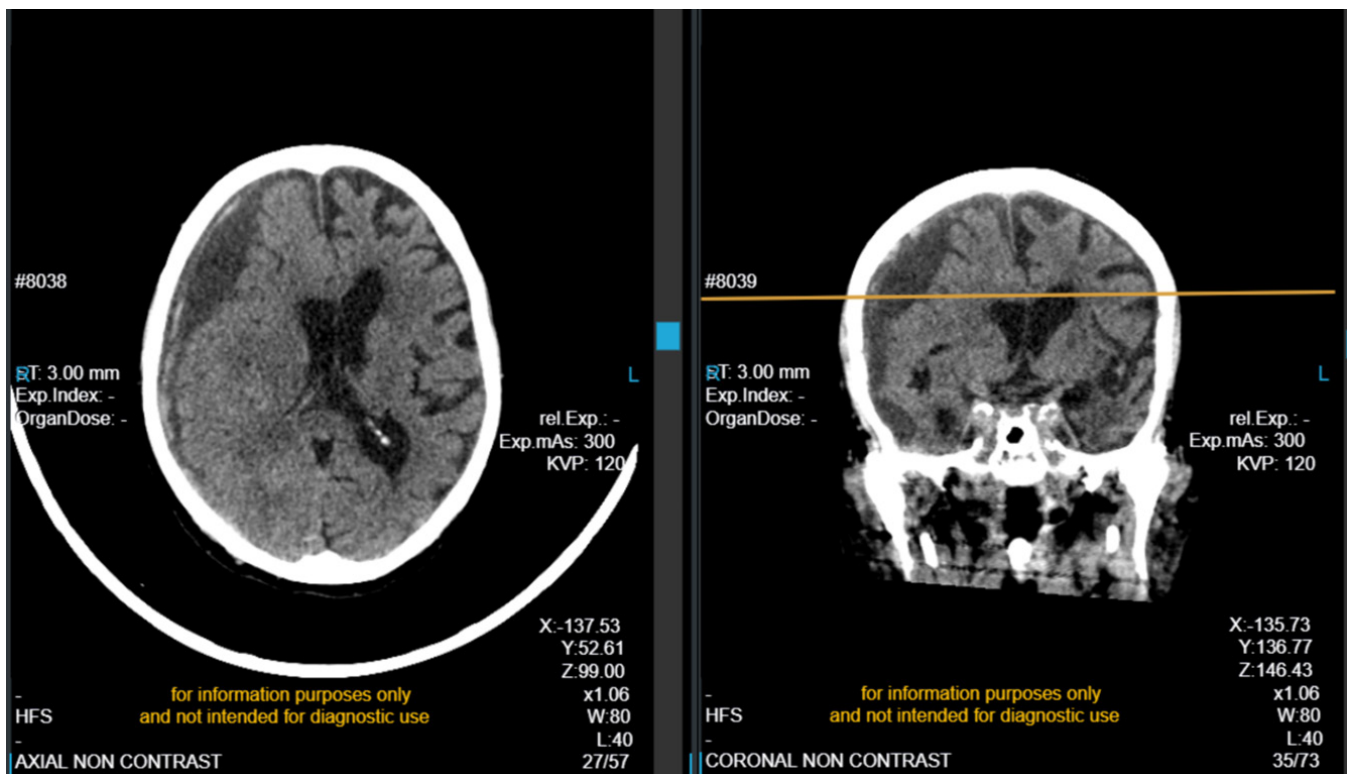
CT Brain demonstrating right subdural hematoma with midline shift (with permission)
